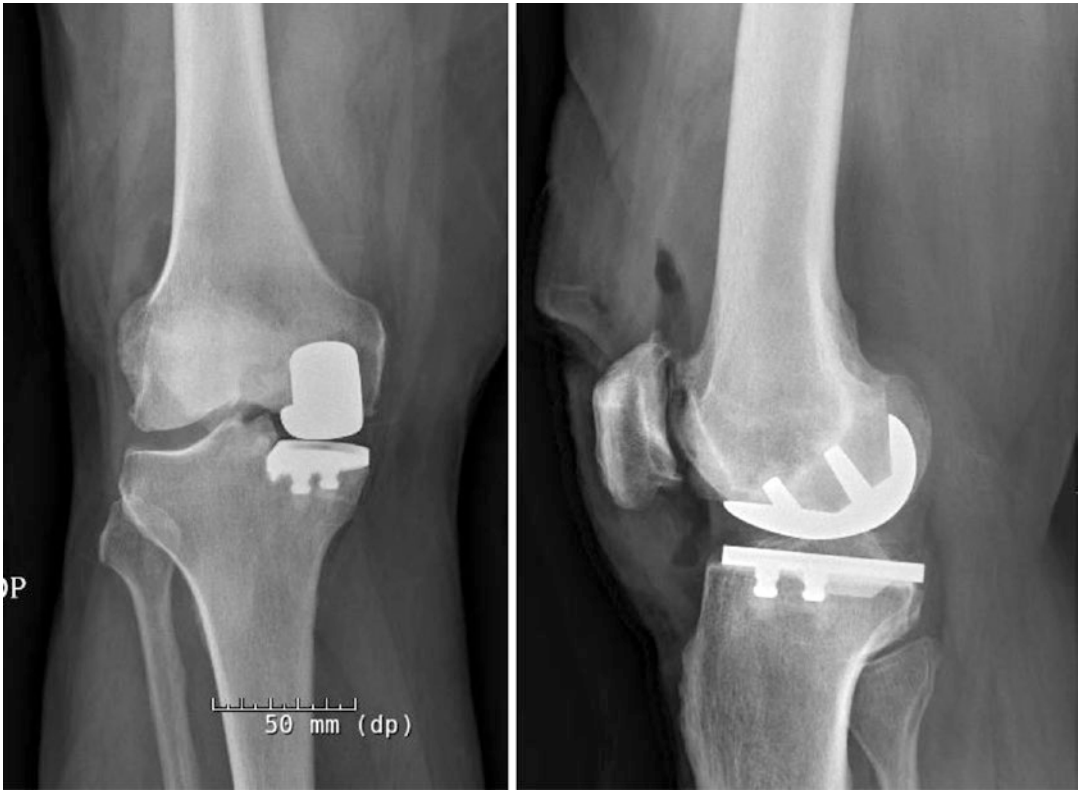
Postoperative radiographs of a 70-year-old patient introduced at the beginning of this chapter
